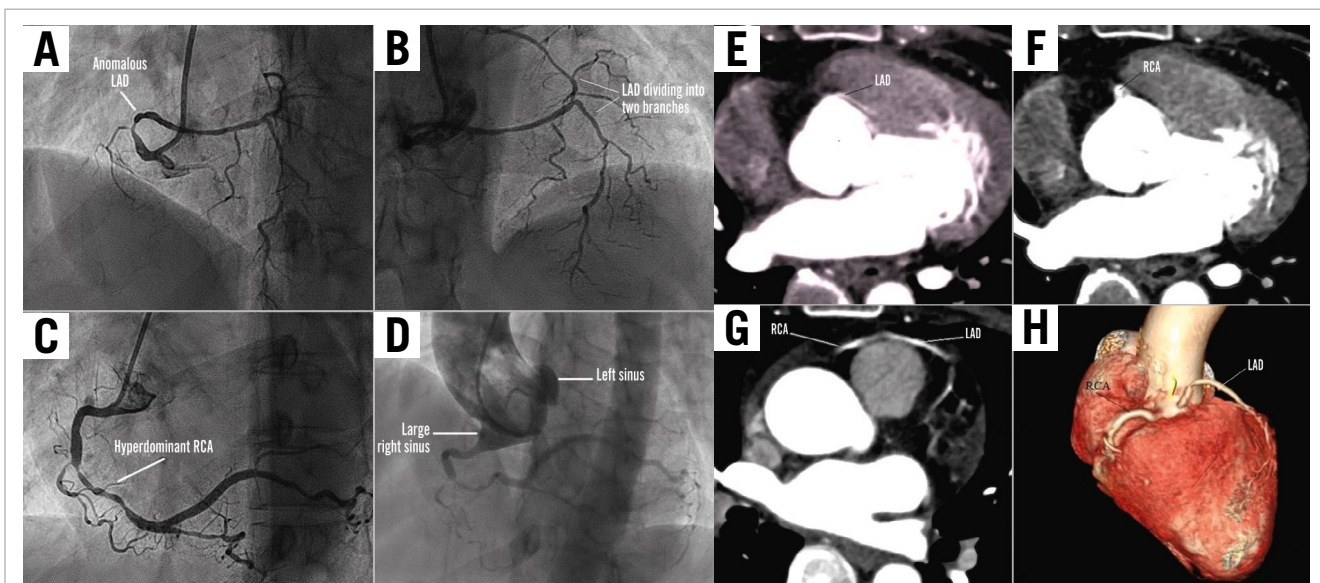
Coronary angiograms: A) LAO cranial view showing the anomalous LAD from the right sinus, with 70-80% disease in the proximal segment and diffuse disease distally. B) AP cranial view showing the anomalous LAD dividing into two branches within the interventricular groove. C) LAO cranial view showing the hyperdominant RCA with 90-95% mid-segment obstruction and diffuse disease in the RPDA. D) Pigtail angiogram of the aortic root in the AP view showing a large right sinus, with no coronaries arising from the left sinus. Coronary CT angiograms: E) Anomalous origin of the LAD from the right sinus. F) RCA arising from the right sinus. G) Distal courses of the LAD and the RCA. H) 3D reconstruction showing the anomalous LAD from the right sinus, with no coronaries arising from the left sinus. 3D: three-dimensional; AP: anterior-posterior; CT: computed tomography; LAD: left anterior descending artery; LAO: left anterior oblique; RCA: right coronary artery; RPDA: right posterior descending artery
